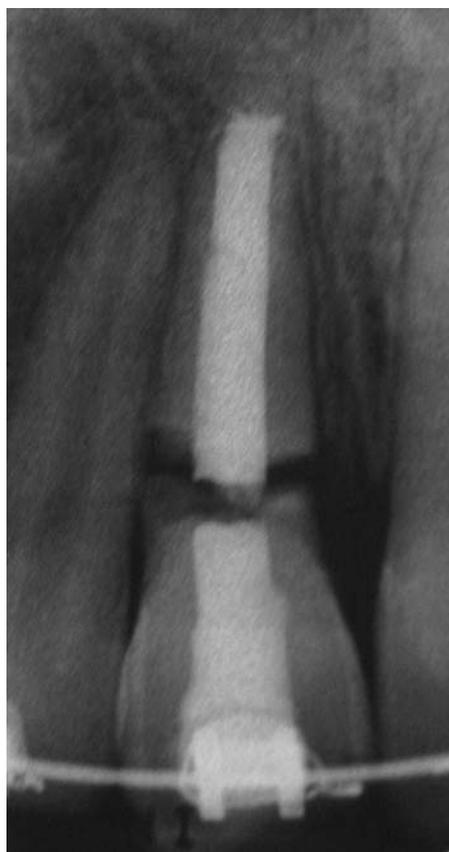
Periapical view of the upper right central incisor prior to space closure.
